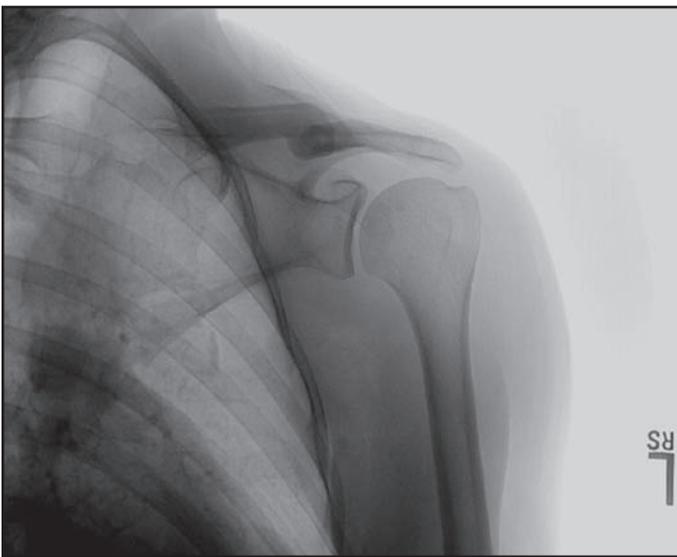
An anterior-posterior radiograph of the shoulder. Observe the glenohumeral joint line and the prominence of the greater tuberosity laterally. This view is sometimes referred to as a Grashey view and is made with the patient's trunk rotated approximately 30 degrees to obtain a true A-P of the scapula and profile the glenohumeral joint.
